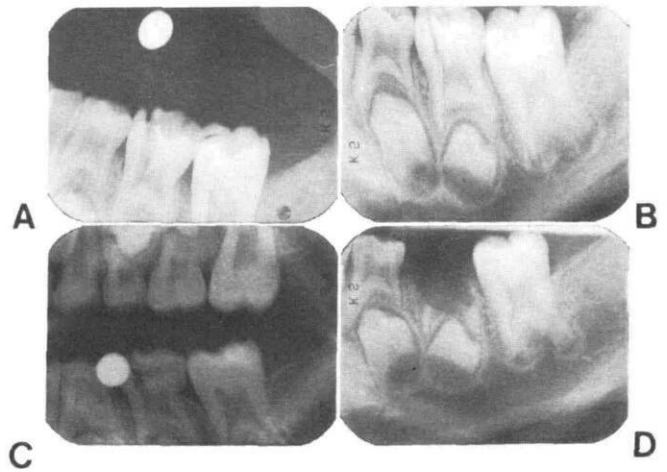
A. A radiograph provided by the referring dentist showed a round, radiopaque object and fracture of the second molar. B. A periapical film showed deep fracture of the primary second molar and a small portion of the radiopaque object just above the mesial cusps. C. A bite-wing radiograph showed the object superimposed upon the fractured mesial cusps. D. In consideration of possible surgical damage to the developing premolar, apical segments of the primary molar roots were left in place.
